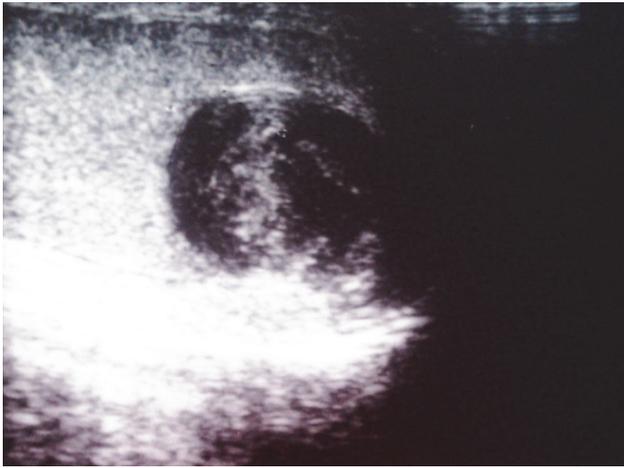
Sonography of the testis shows a circumscribed, heterogeneous, predominantly hypoechoic mass in the right testis, 13 mm in diameter.
